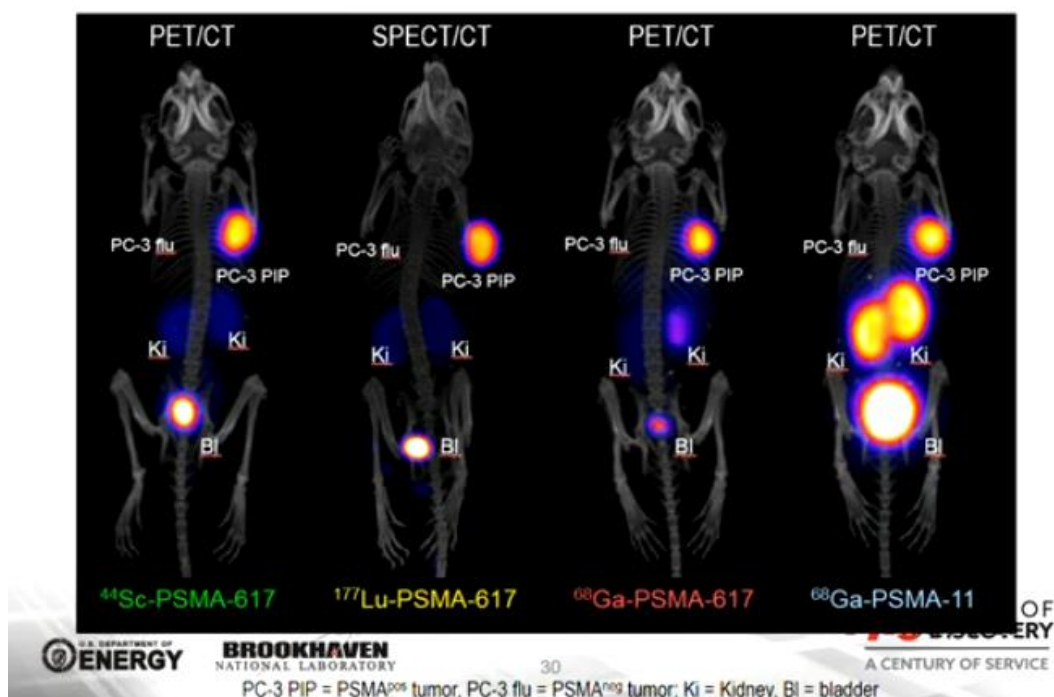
圖 十四、(A)Ga-68 與 Sc-44 的 β^+ 的平均能量比較；(B)PSMA-617 分別標誌 Sc-44、Lu-177 及 Ga-68 與 Ga-68-PSMA-11 於前列腺癌小鼠模式照影圖（作者摘錄）
